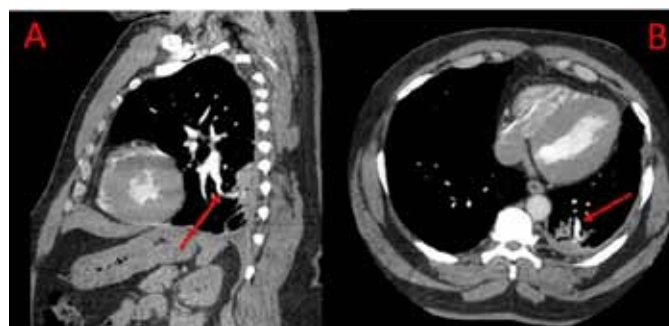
Computed tomography scan of the chest with contrast (at the time of presentation). (A): Typical "Cornet tail" sign with bronchovascular bundles extending from hilum to the area of Rounded atelectasis (red arrow), and (B): Air bronchogram in the center of the area of Rounded atelectasis (red arrow).
